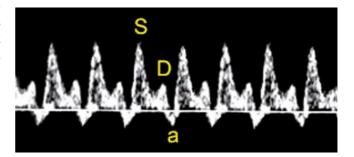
Doppler examination of the inferior vena cava with normal flow velocity waveforms
